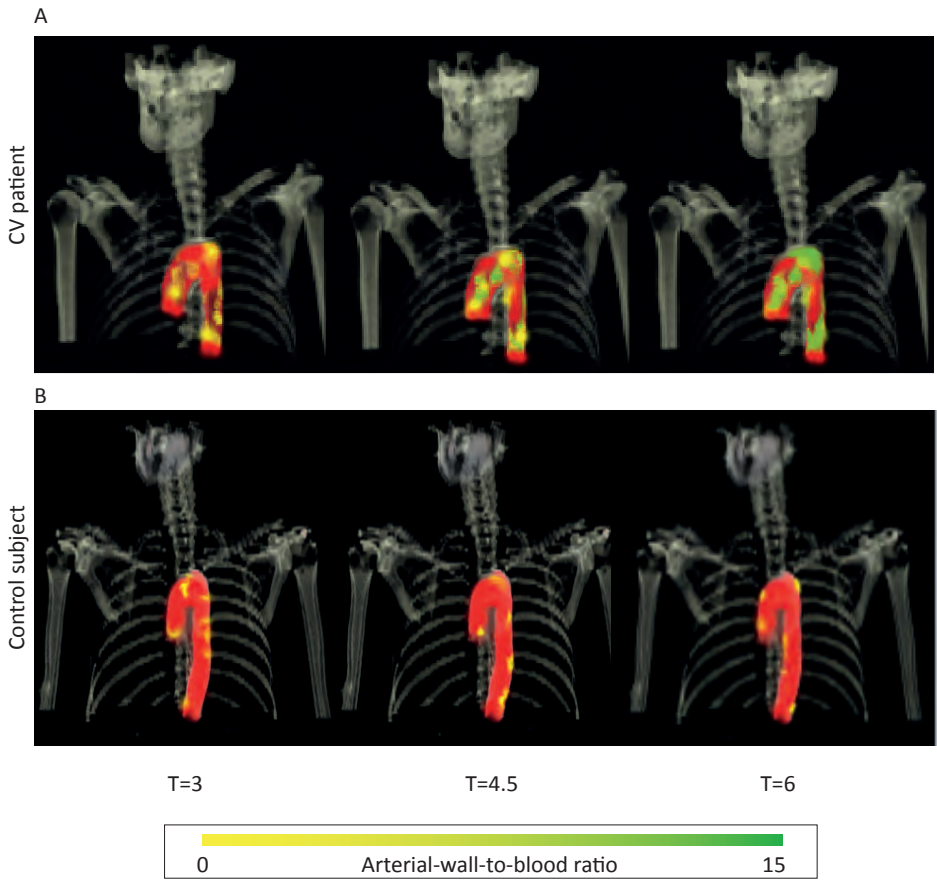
PBMCs accumulation over time portrayed with SPECT/CT
